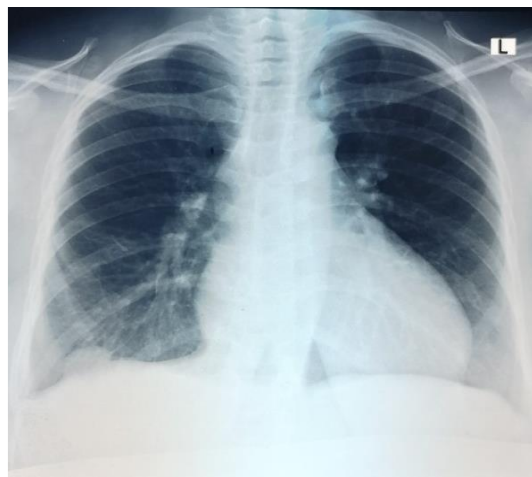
Chest x-ray showing full lung expansion after chest tube removal
